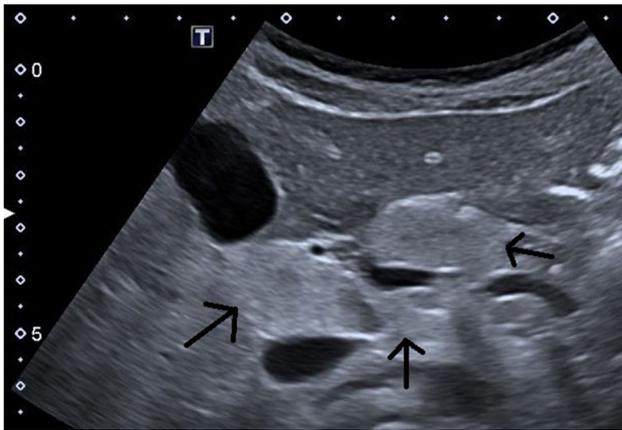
Abdominal ultrasonography with a convex probe. Perioral and hilar echogenic and enlarged lymph nodes are depicted (arrow). Since we demonstrate the abdominal lymph nodes with a curved probe, the echogenic foci are seen as diffusely increased echogenicity in the lymph nodes because of limited axial resolution
